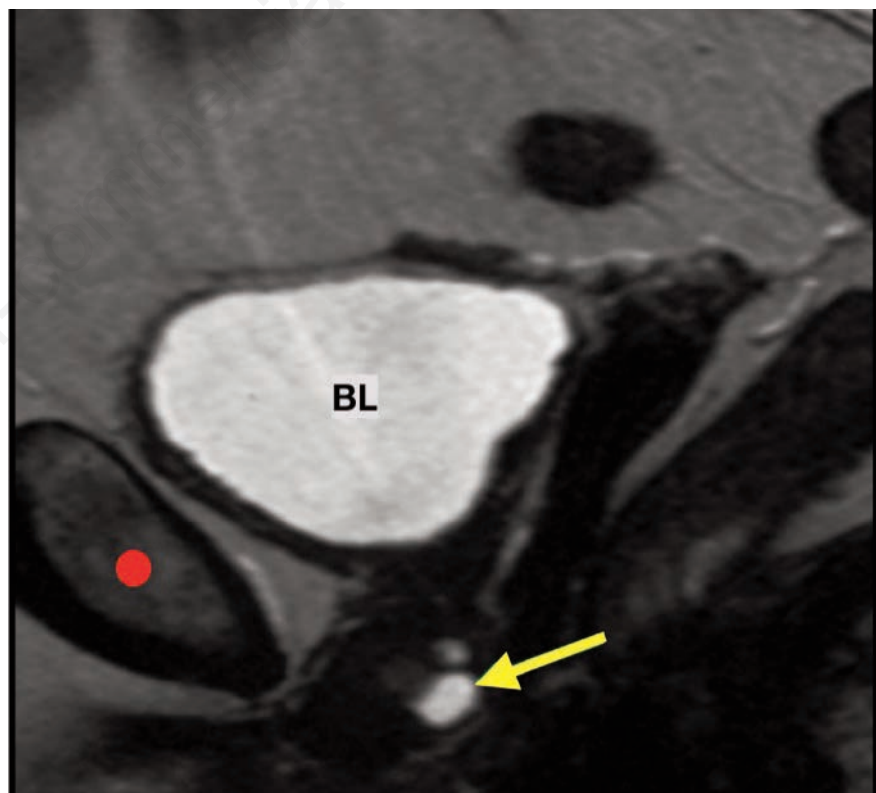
Magnetic resonance imaging (with contrast medium) of female urethral diverticulum (BL: bladder; yellow arrow: urethral diverticulum; red circle: pubis). Reproduced with permission from: Gugliotta G, Calagna G, Adile G, et al. Use of trans-labial ultrasound in the diagnosis of female urethral diverticula: A diagnostic option to be strongly considered. The Journal of Obstetrics and Gynaecology Research 2015;41:1108-14. doi:10.1111/jog.12676
